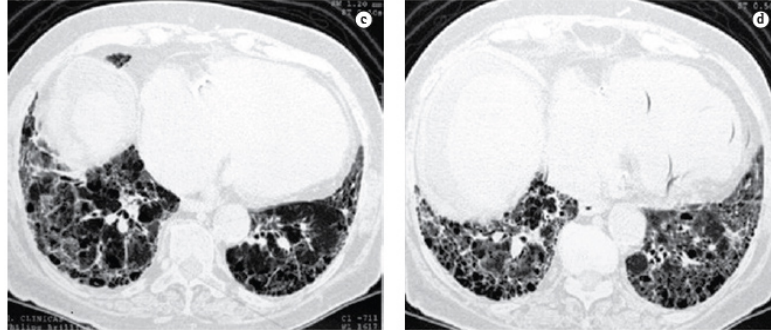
High-resolution computed tomography (HRCT) from an IPF patient. Peripheral reticular abnormalities with minimal ground-glass opacities and cystic structures surrounded by thickened white lines (honeycombing).
